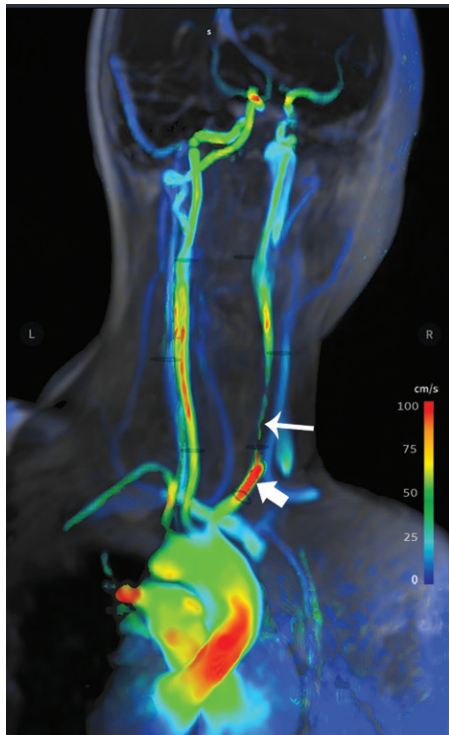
Four-dimensional flow MRI covering the thoracic aorta and cerebral arteries. Three-dimensional velocity rendering shows increased velocity in the proximal right common carotid artery (thick arrow) upstream of a long segment of tight stenosis (thin arrow). Note that the right subclavian artery is occluded.
